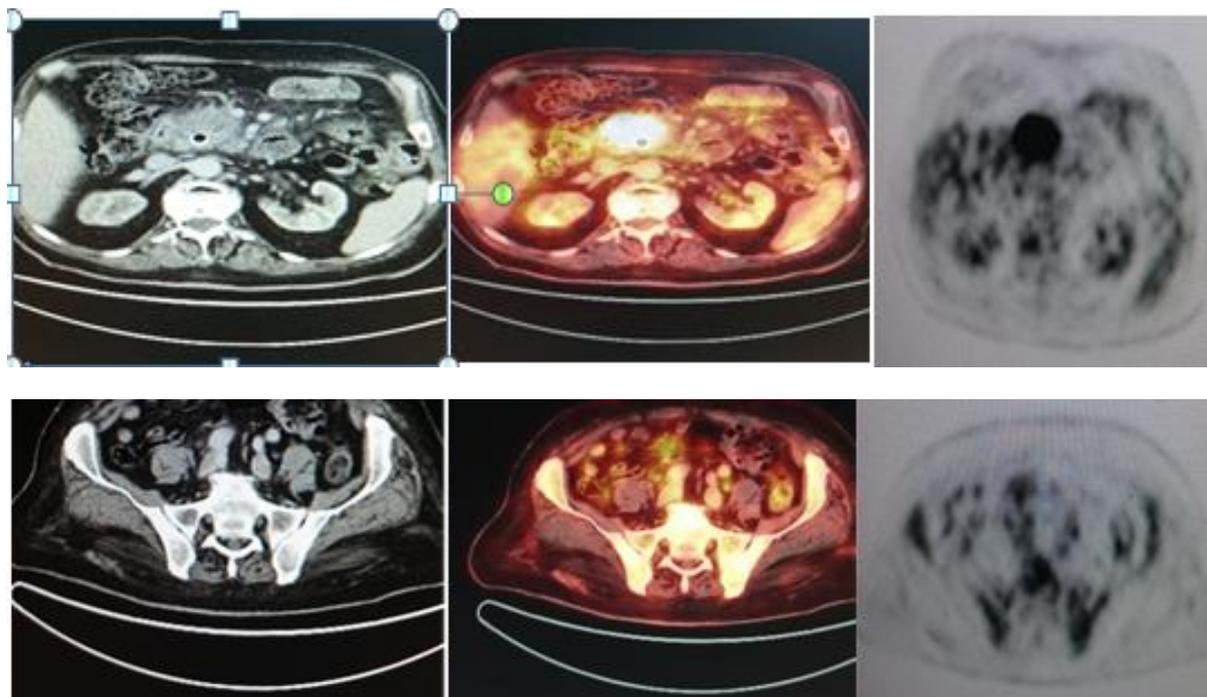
50 years old male patient presented by pancreatic head mass, reported in CT underwent ERCP, PET /CT revealed pancreatic lesion and peritoneal nodule.
